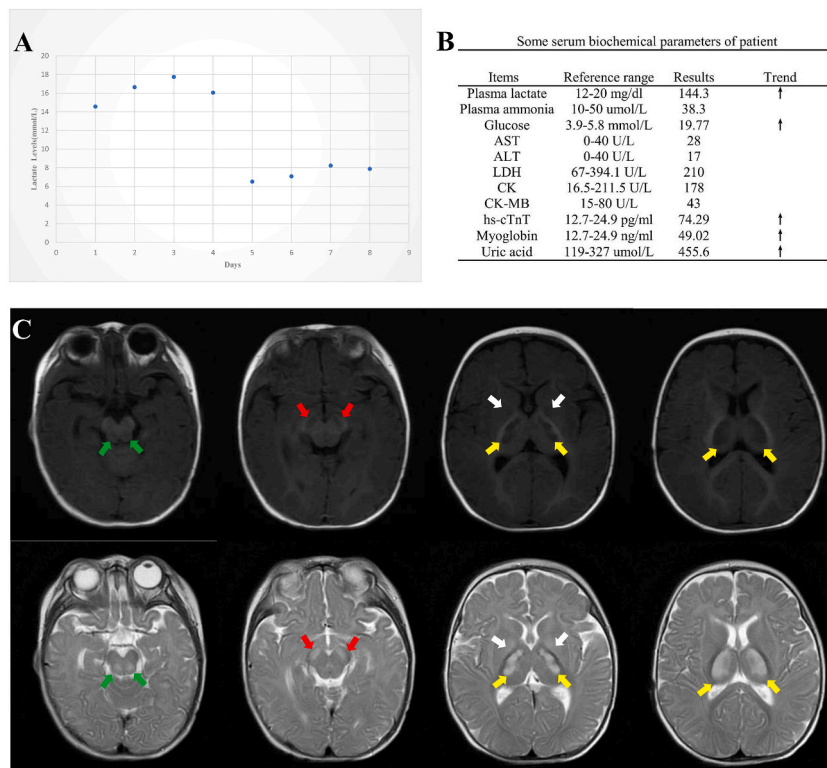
The results of the clinical examinations. (A) Laboratory parameters of the patient. (B) Daily plasma lactate levels for the patient, from admission. CSF-TP, cerebrospinal fluid total protein; hs-cTnT, high-sensitivity cardiac troponin T; LDH, lactate dehydrogenase; CK, creatine kinase; AST, aspartic transaminase; ALT, alanine aminotransaminase; PT, prothrombin time; APTT, activated partial thromboplastin time; INR, international normalized ratio. (C) MRI images taken during hospitalization. The MRI demonstrated diffuse and symmetrical abnormal signals in bilateral cerebral foot (red arrowheads), posterior portion of the brain stem (green arrowheads), basal ganglia (white arrowheads) and thalamus (yellow arrowheads).
